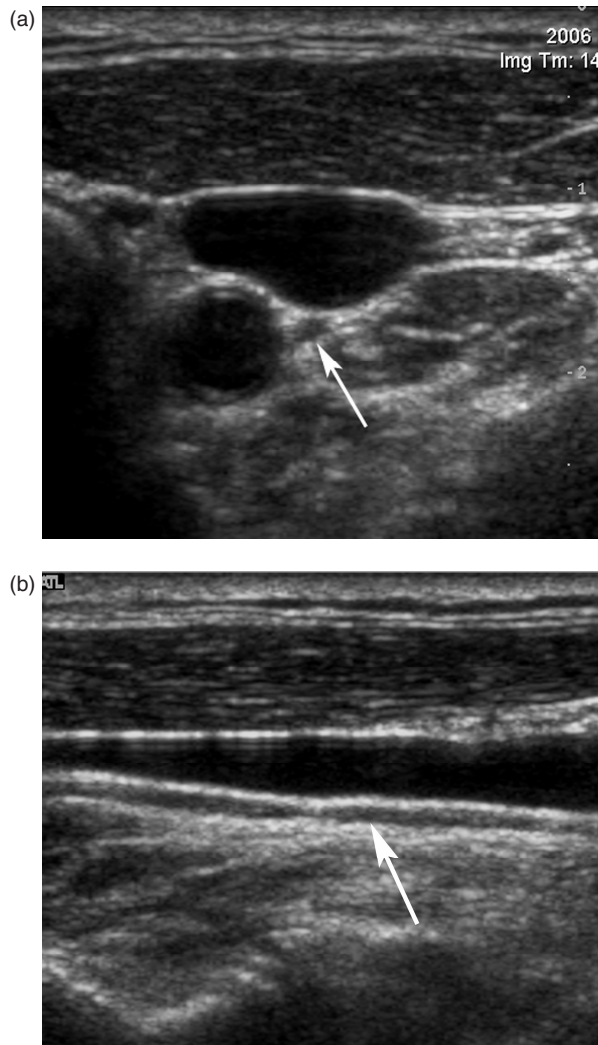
Ultrasound of the carotid sheath demonstrating the vagus nerve (arrow) in both the transverse (a) and longitudinal (b) plane.
